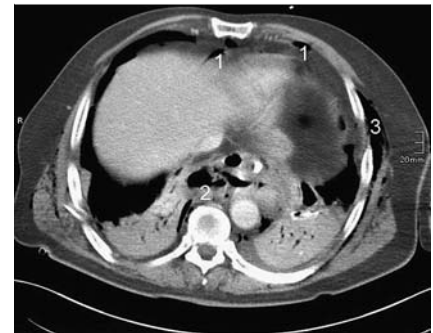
Computed tomography (CT) scan showing air within the abdomen (1), air in the lower mediastinum (2), and subcutaneous emphysema (3).
